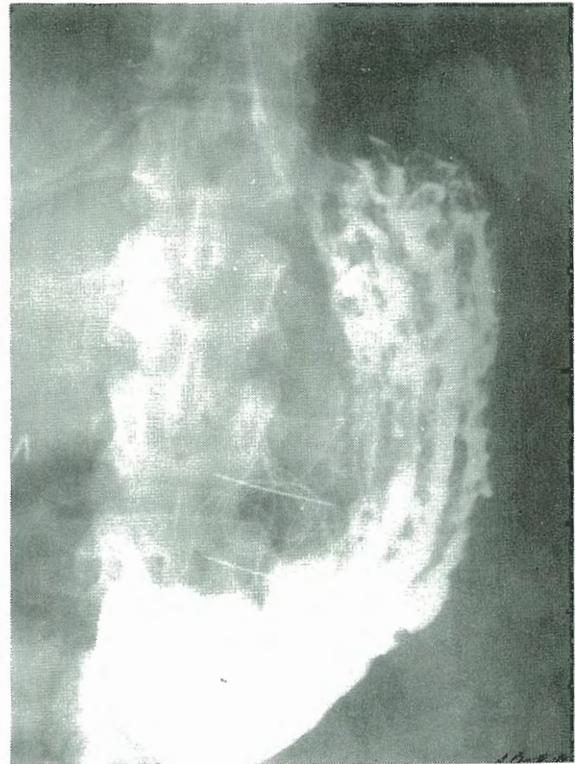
Roentgenogram of the abdomen. Note the abnormal soft tissue shadowing of the RAMH and epicardial pacemaker wire, which was entered into the abdomen on the beginning site of it.
